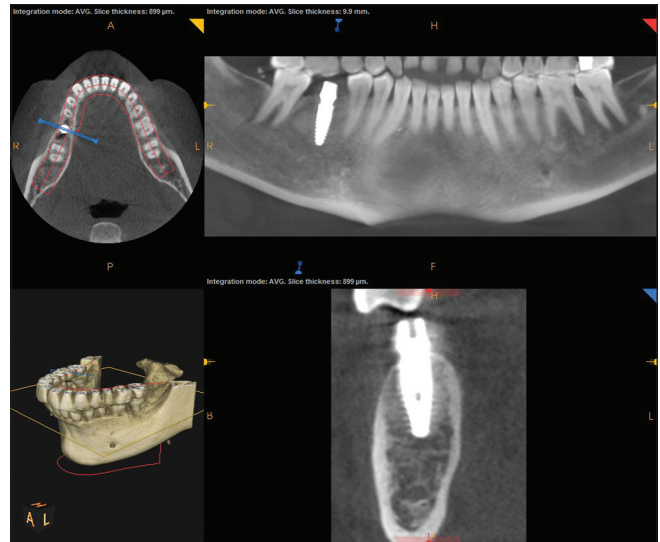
Preoperative assessment of bone by cone beam computed tomography
